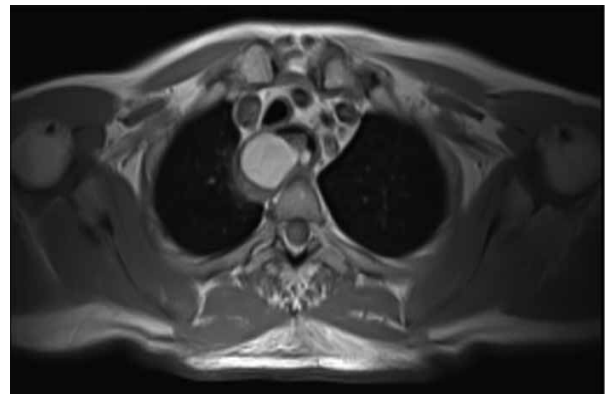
T1W (a) and T1W FS (b) chest MRI images showing the predominantly fatty composition of the intramurally spread of the oesophageal lesion. No evidence of invasion to adjacent structures is shown.
